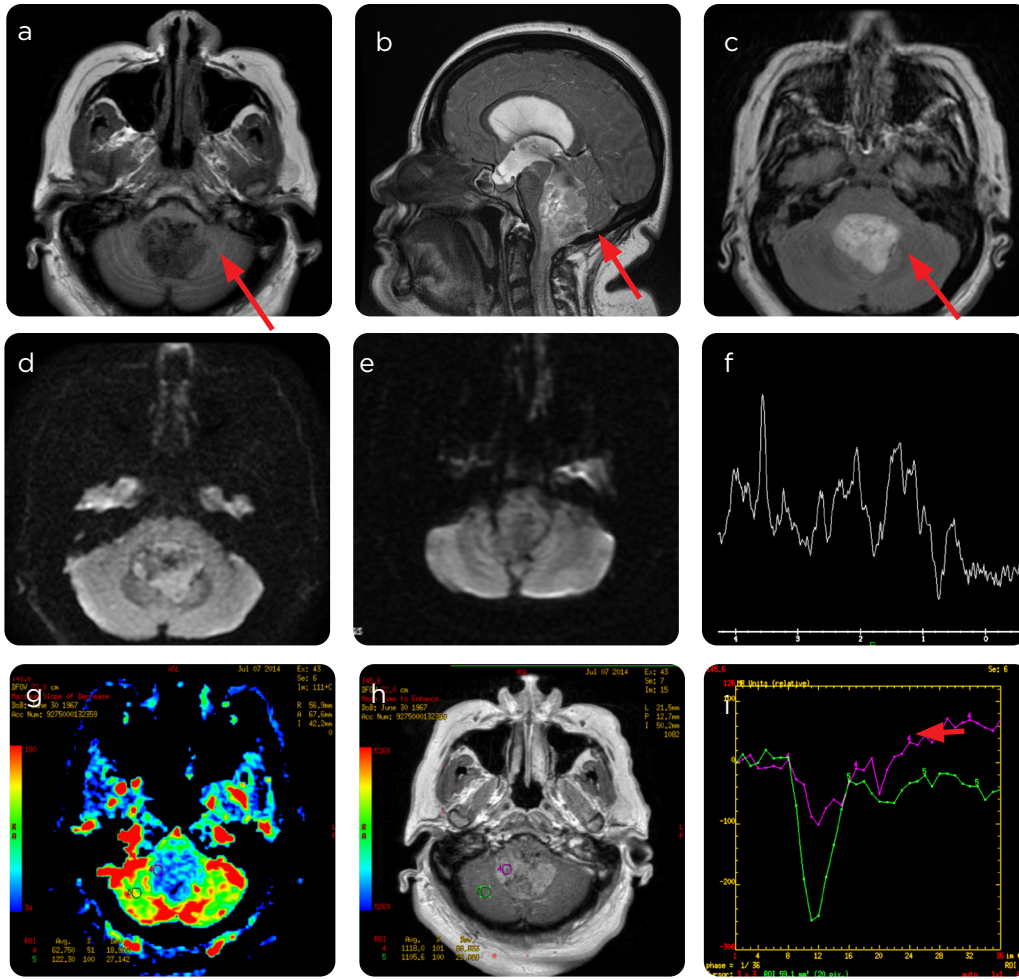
Ependymoma in the IV ventricle. a) Axial MRI sequence with T1 information, low to intermediate signal. b) With contrast medium: intense enhancement and discretely heterogeneous. c) Sequence with T2 information: predominantly high signal. d) Diffusion sequence: intermediate signal. e and f) Perfusion: high cerebral blood volume without return to baseline.
